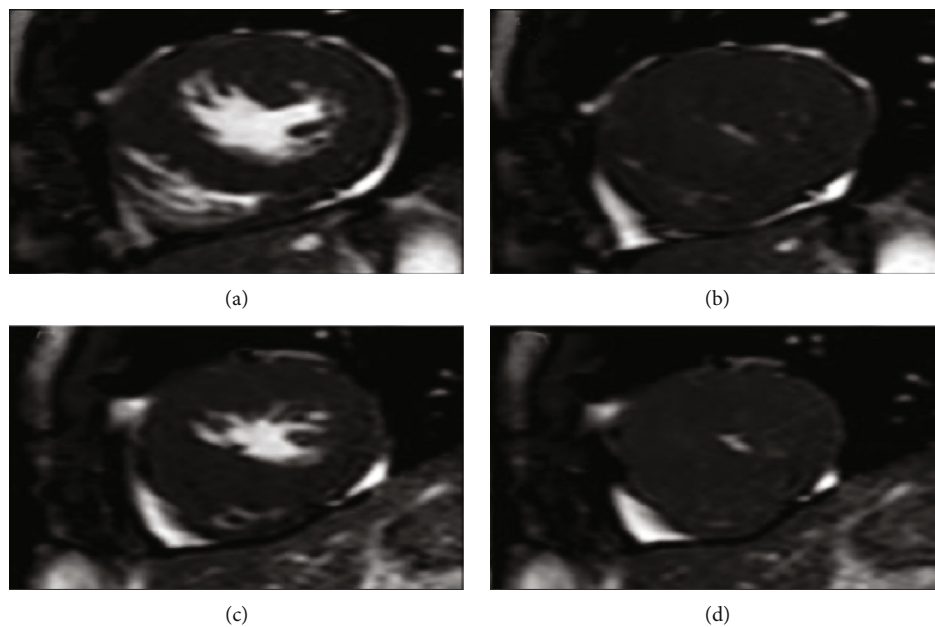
MRI short-axis view showing mid-LV chamber at the end of diastole (a) with obliteration of cavity in end systole (b). MRI short-axis view showing apex in end diastole (c) with obliteration of cavity in systole (d). Hypertrophy can be appreciated in both the left and right ventricles.
